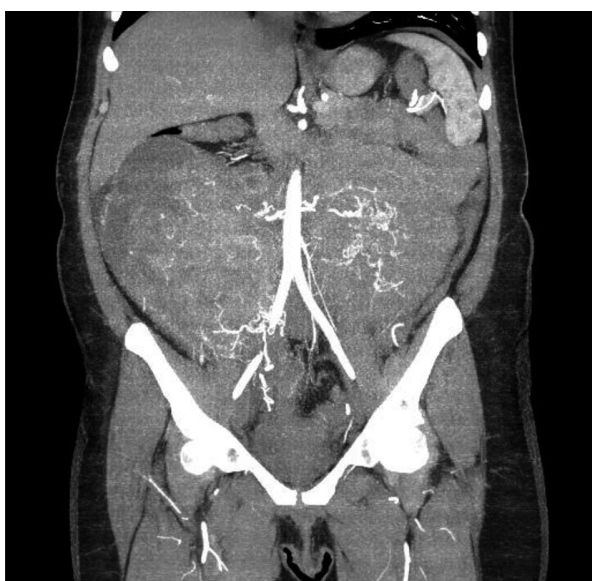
Computed tomography scan, frontal section: transposition of abdominal organs by fibroid mass
